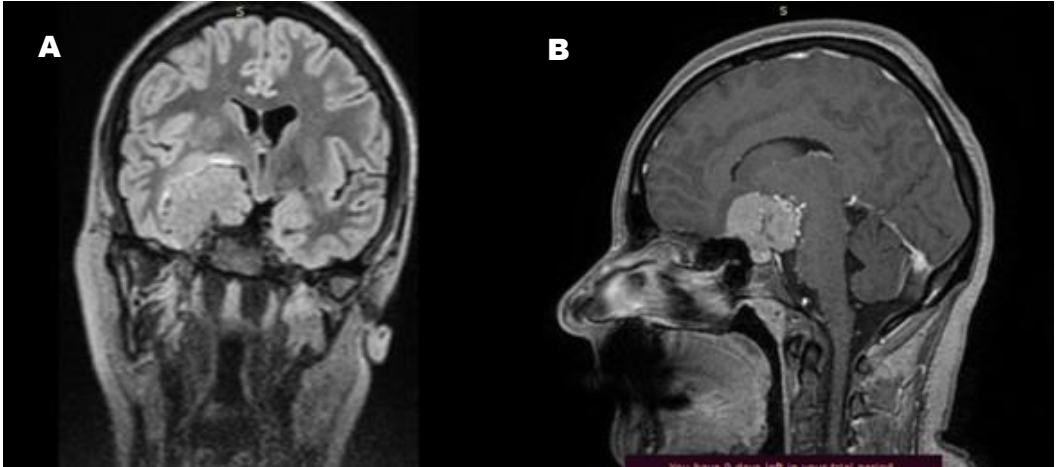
Craniocerebral Magnetic Resonance Imaging (MRI) of a tuberculum sellae meningioma. (A) sagittal section.; (B) coronal section.
